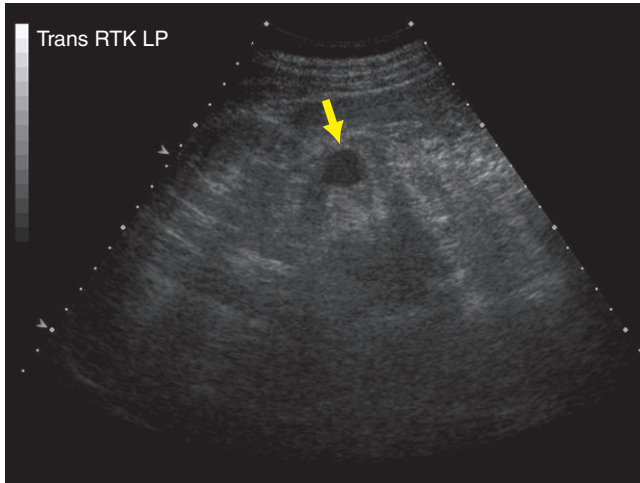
Real-time ultrasound performed through the mass (arrow) demonstrates it is very hypoechoic compared to surrounding peritoneal fat.
